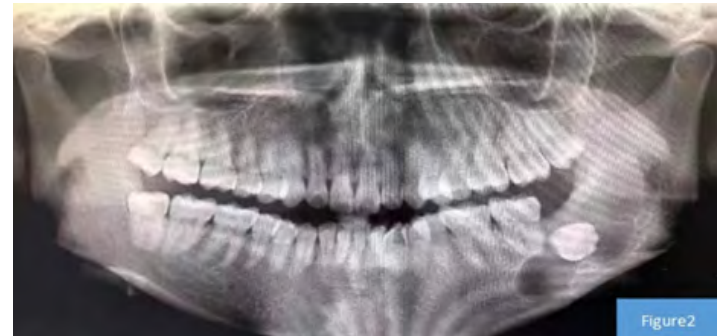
Expression is the result of the patient’s preoperative oral X-ray examination.
